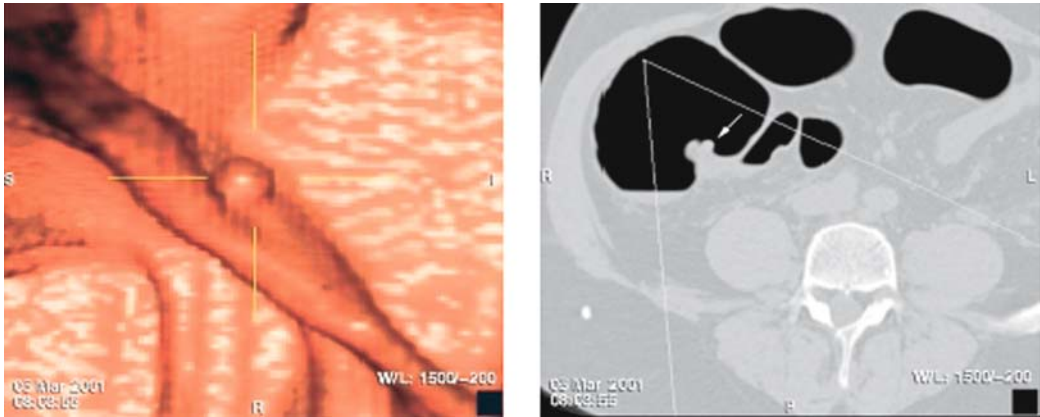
Multislice CT colonography.
